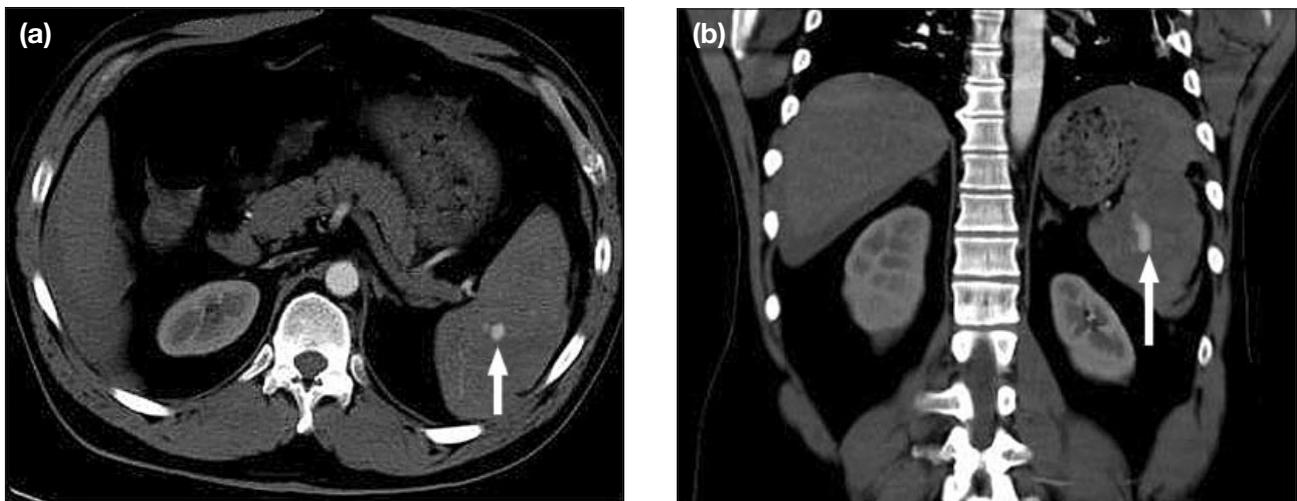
Splenic injury following blunt abdominal trauma. (a) Axial computed tomography scan shows focal arterial contrast material extravasation representing active haemorrhage (arrow); and (b) coronal reformat demonstrating focal arterial contrast material extravasation.
